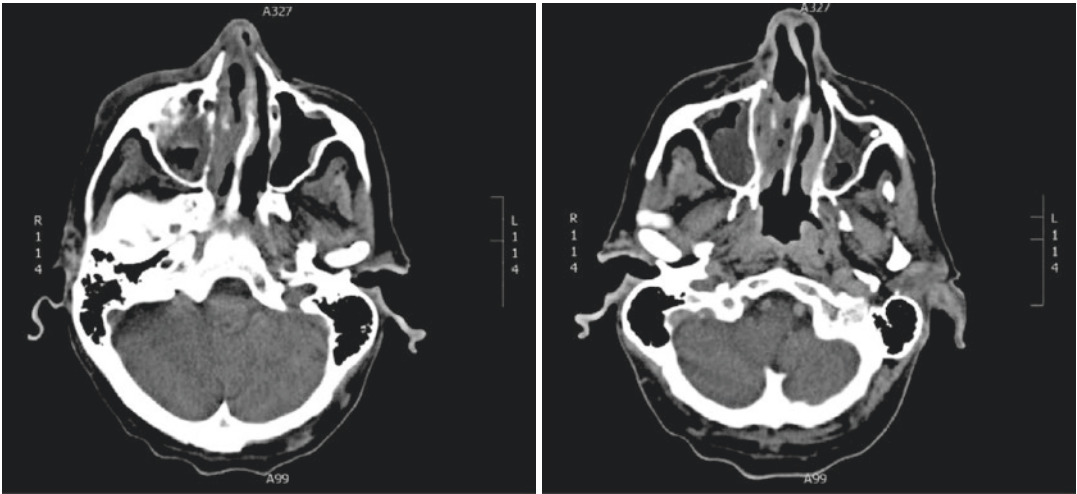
CT scan of the paranasal sinuses
